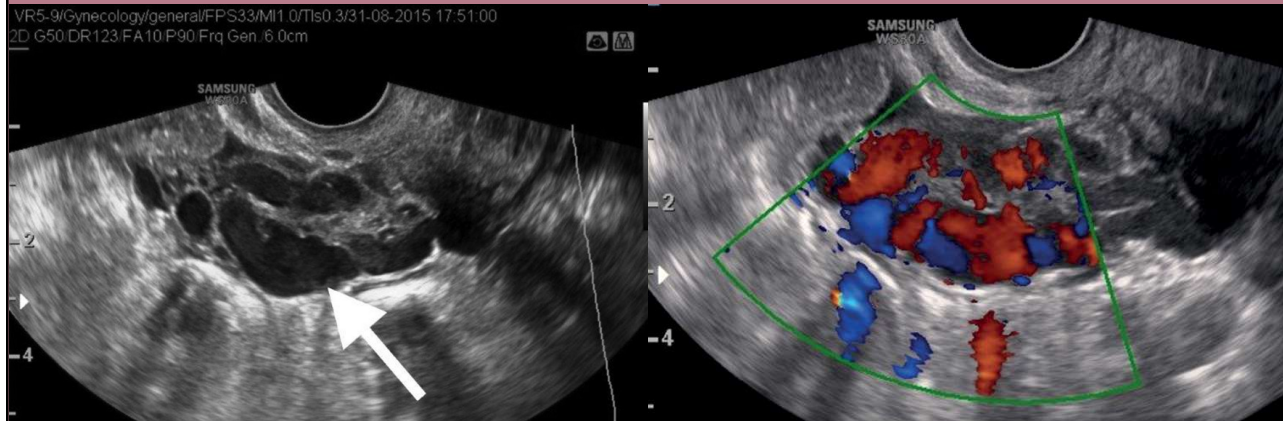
B- mode and color Doppler imaging of a dilated left parametrial venous plexus (arrow) initially misdiagnosed as a hydrosalpinx.<sup>21</sup>
